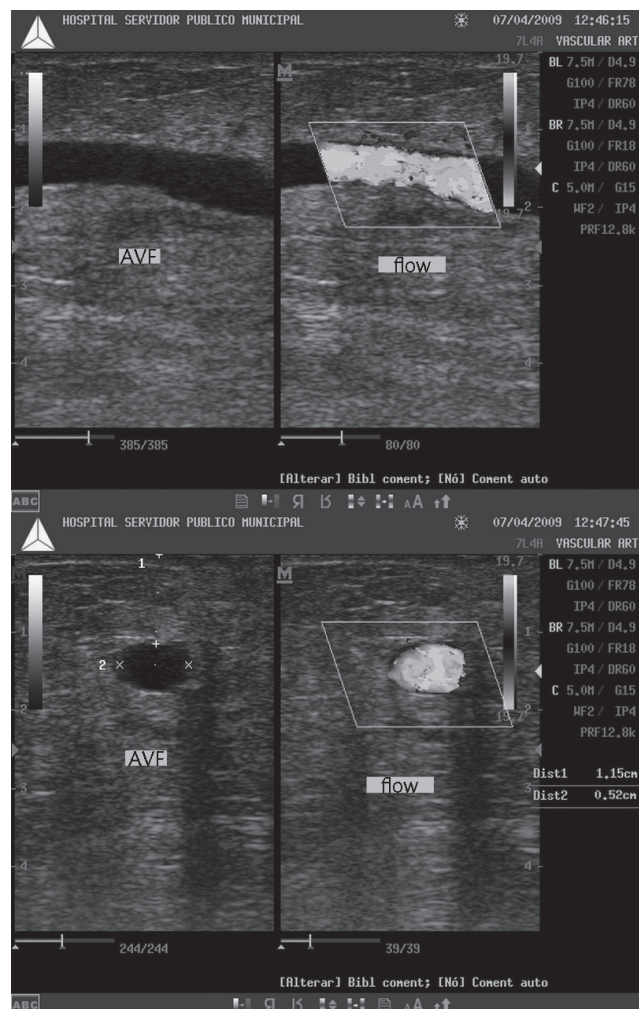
Doppler ultrasound on postoperative day 10 showing AVF with flow. Notice the small distance between the fistula and the skin, and the good diameter of the vein.
